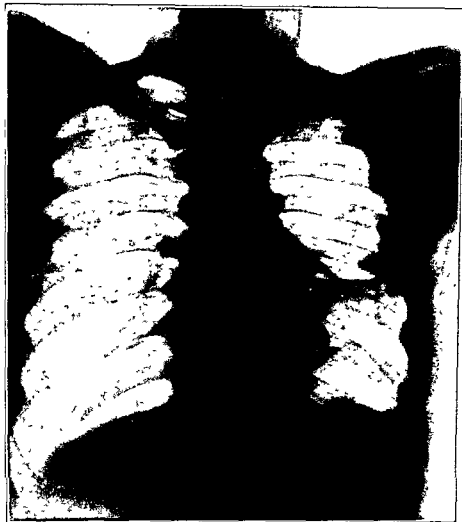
Note the huge size of this check-valve cavity. Two years and eighteen months have elapsed since the x-ray in Fig. 43. Breath sounds over the left upper lobe are still emphysematous. One would hardly suspect an underlying cavity. The intercostal spaces and mediastinum still maintain their normal position.
